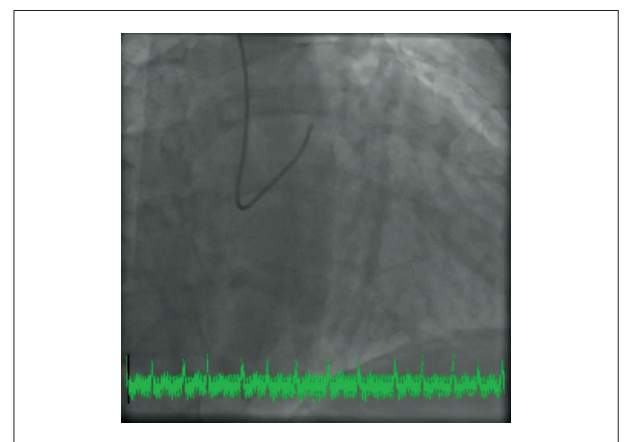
A) Transthoracic echocardiography revealing multiple tortuous ‘rosary-like’ folds (white arrow), raising the possibility of a coronary fistula. B) Coronary angiography early contrast filling and C) late contrast filling showing a large-caliber complex Sakakibara type B fistula (white arrows) arising from the left main coronary artery (blue arrow). D) Multislice computed tomography angiography detailing the tortuous anatomy of the coronary fistula between the left main coronary artery and the coronary sinus, with multiple folds located anteromedially to the right pulmonary artery. E) Three-dimensional CT reconstruction of the coronary fistula. F) Intraoperative picture of the surgical fistula obliteration procedure showing the multiple tortuous pathways of the coronary fistula (white arrows). Ao: aorta; AP: pulmonary artery trunk; APD: right pulmonary artery.
